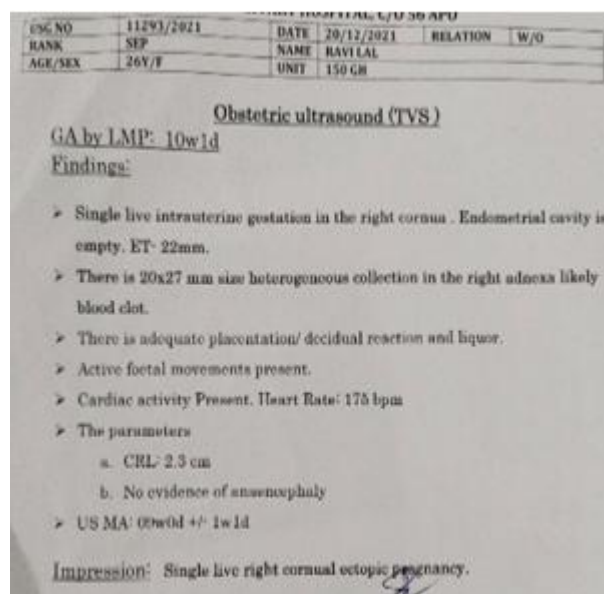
Ultrasonography report suggestive of Right Cornual ectopic pregnancy
